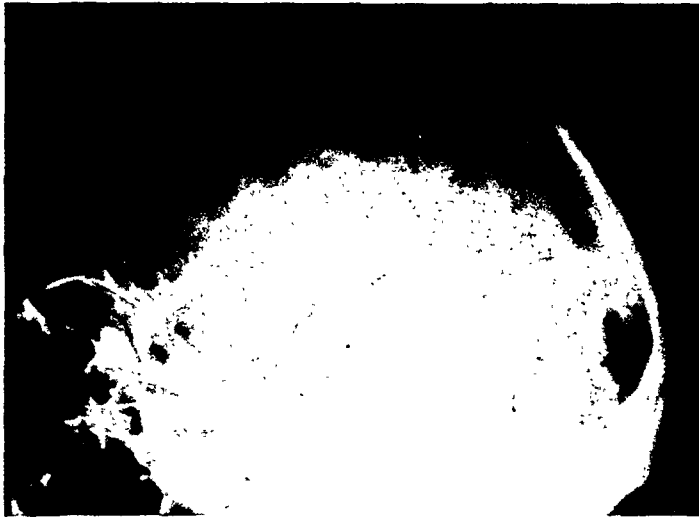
Roentgenogram revealing multiple linear fracture in the left temporal and parietal bones.
